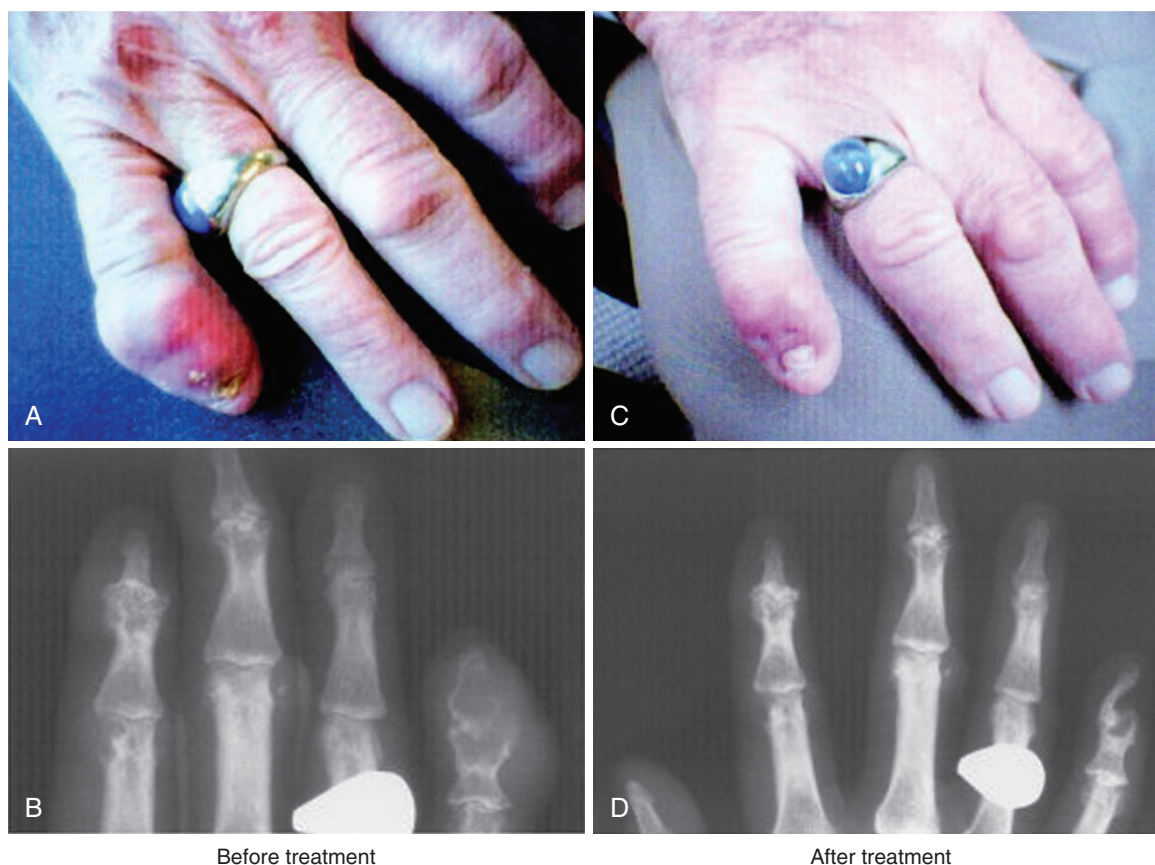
Photographic and radiographic evidence of tophus resolution after pegloticase treatment. A, Large draining tophus on fifth distal interphalangeal (DIP) joint, before treatment. B, Corresponding radiograph showing soft tissue swelling and bony erosions in fifth DIP joint, before treatment. C, Resolution of tophus on fifth DIP joint after 12 weeks of treatment. D, Corresponding radiograph showing resolution of soft tissue swelling in fifth DIP joint, a decrease in bony erosions, and thickening of bone cortex at this joint, 15 months after termination of therapy. (From Baraf HS, Matsumoto AK, Maroli AN, Waltrip RW: Resolution of gouty tophi after twelve weeks of pegloticase treatment, *Arthritis Rheum* 58:3632, 2008.)
